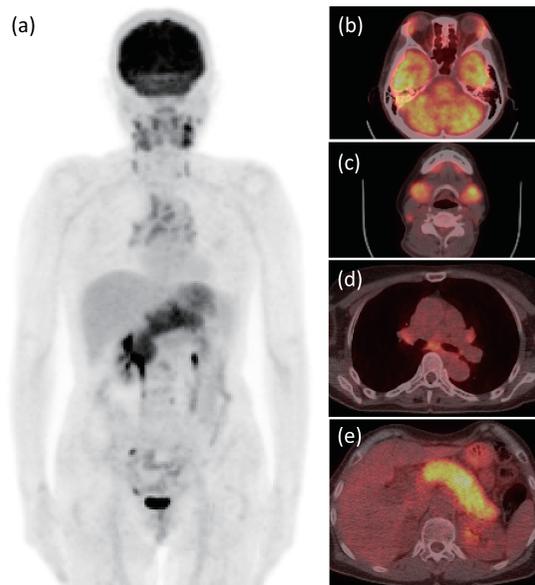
The FDG-PET findings in a patient with IgG4-related pancreatitis.
